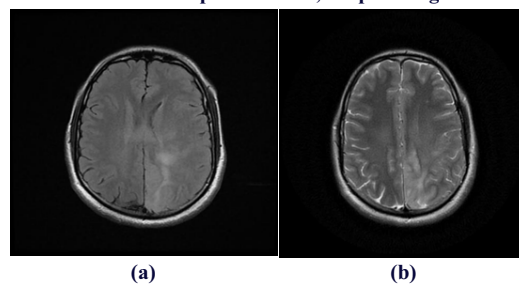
Fluid attenuated inversion recovery (FLAIR), T2 axial image showing ill defined hyperintensity in left posterior region causing effacement of adjacent sulci suggestive of vasogenic edema.
